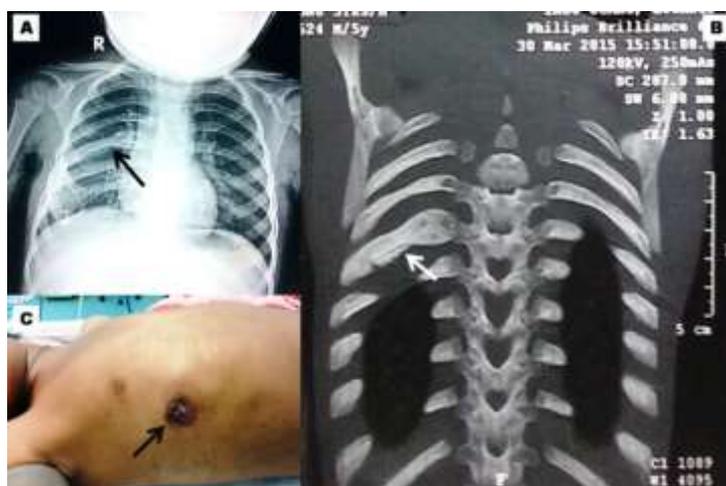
(A): Chest X- ray showing hypertrophy of the 6th rib [Black arrow] (B): CT scan Chest showing hypertrophy of the 6th rib on the right side with partial destruction [White arrow] (C): Clinical photograph of the patient with a discharging sinus over right lateral chest wall [Black arrow]
